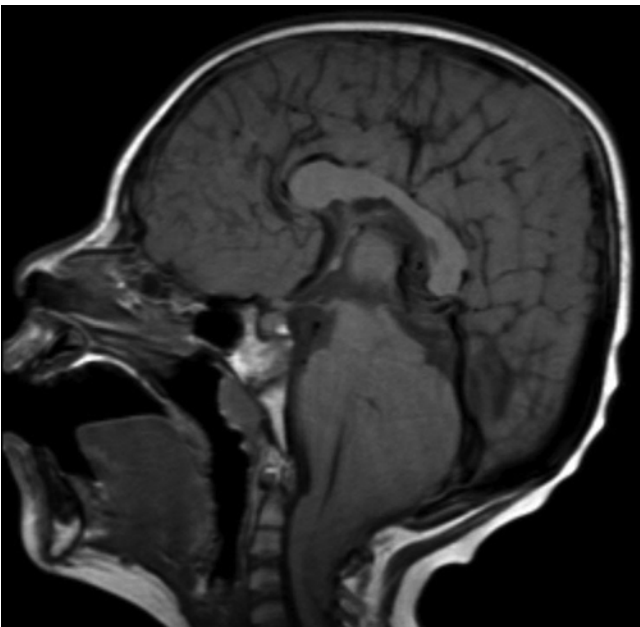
Case 1. Sagittal T1-weighted image showing partial RS in the setting of Chiari malformation Type II. The cerebellar tonsils extend through the foramen magnum to approximately the C-4 level, and there is flattening and caudal displacement of the fourth ventricle. Additional findings associated with Chiari malformation Type II included tectal beaking and stenogyria.
